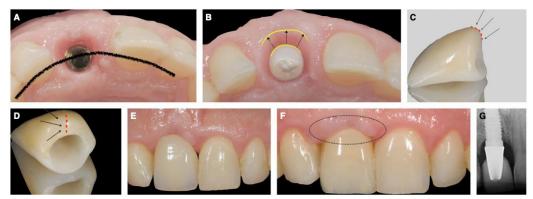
(A) The center of the implant corresponds to the cingulum of the adjacent teeth. (B) Occlusal view of the final zirconium abutment. The distance A-B will be filled by the cervical contour of the final crown (marked by inner and outer semicircles shown in yellow). (C, D) The definitive lithium disilicate crowns with a cervical contour (marked by red dashed lines and black arrows) out of the physiologic parameters determined by the implant position associated with a vertical finish line geometry. (E) Provisional restoration in place. (F) One-year follow-up of the definitive crown showing signs of tissue reaction (marked by black dashed-line oval). (G) Periapical radiograph of the definitive crown.
